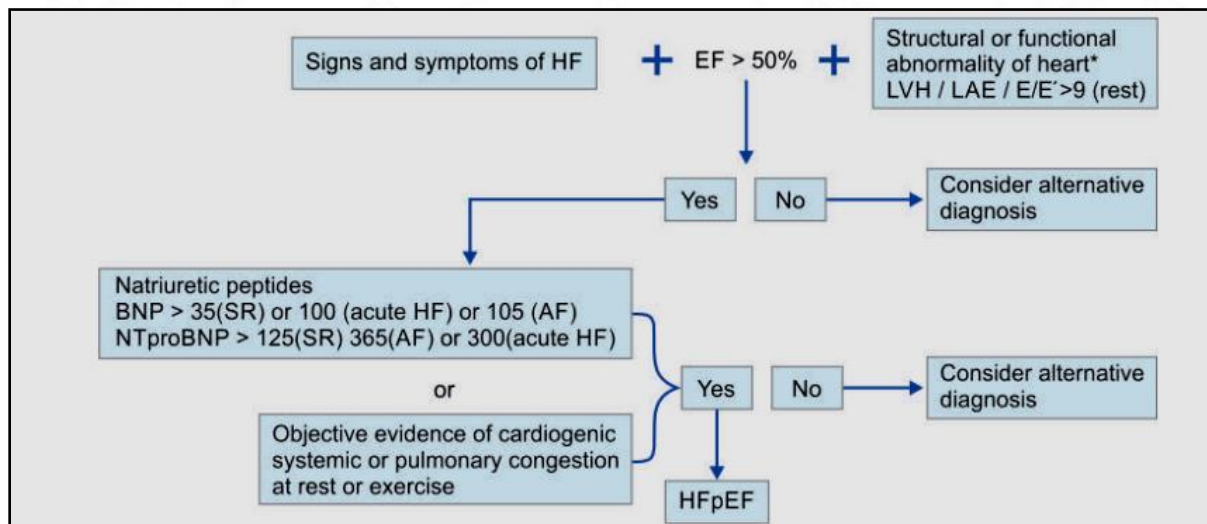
Algorithm for diagnosis of HFpEF. *LV mass index ≥95 gm/m² (female), ≥115 gm/m² (male), relative wall thickness >0.42 LA volume index >34 mL/m² (SR) >40 mL/m² (AF) PA systolic pressure—TR velocity at rest >35 mm Hg/>2.8 m/s at rest. On exercise TR velocity >3.4 m/s, E/E' >15; BNP, B-type natriuretic peptide; E/E' ratio, early filling velocity on mitral inflow Doppler/early relaxation velocity on tissue Doppler; LA, left
